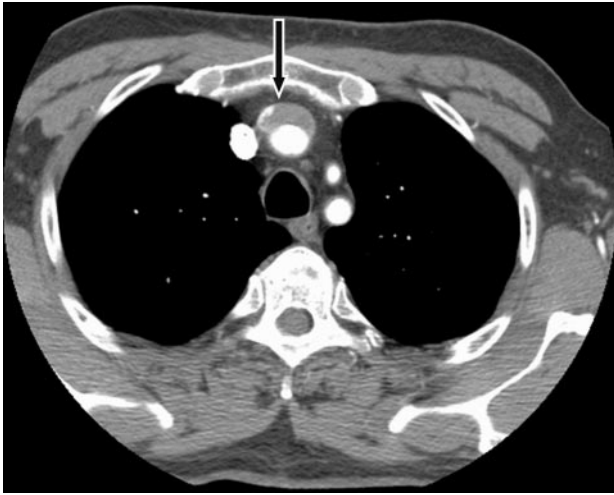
Left brachiocephalic vein mimics an intramural hematoma on CT. Axial CT image demonstrates a low-attenuation crescent of material anterior to the innominate artery. CT indicates computed tomographic imaging.
